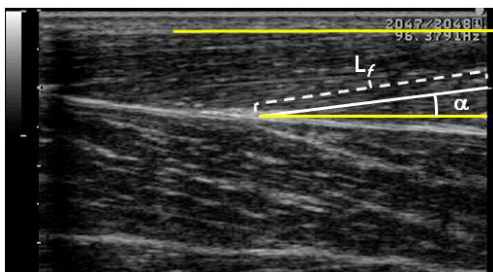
Measurements of fascicle length (L_f) and pennation angle (α) from ultrasound image of the tibialis anterior.
